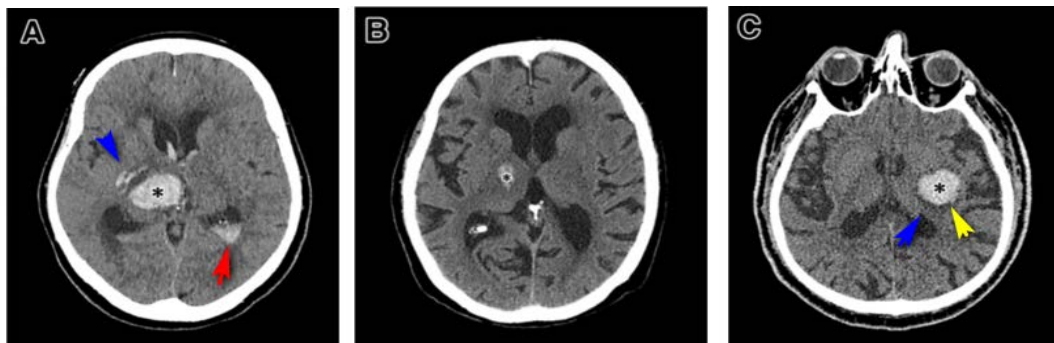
Deep hemispheric hemorrhages in axial computed tomography scans. Note entire thalamus (asterisk) affecting the posterior limb of the internal capsule (blue arrowhead) with intraventricular hemorrhage (red arrow) (A); hemorrhage involving the anterior part of the thalamus – asterisk (B); basal ganglia hemorrhage (asterisk) affecting the posterior limb of the internal capsule (blue arrowhead) and the posterior part of the left putamen (yellow arrowhead) (C).
